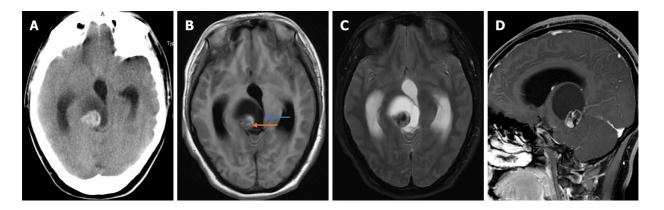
Computed tomography image and magnetic resonance imaging images of the mass before surgery. A: Computerized tomography image revealing a solid cystic mass in the right thalamus; B, C: T1 and T2 imaging showing heterogeneous signals and cystic and solid components; D: Inhomogeneous enhancement in the solid part was observed after administration of a contrast agent.
